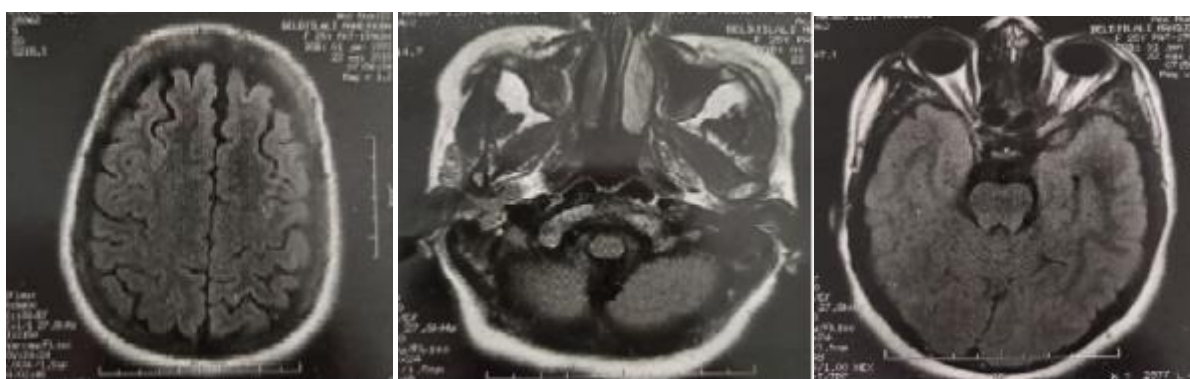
Brain MRI: (axial sections, T2 sequences): normal.
